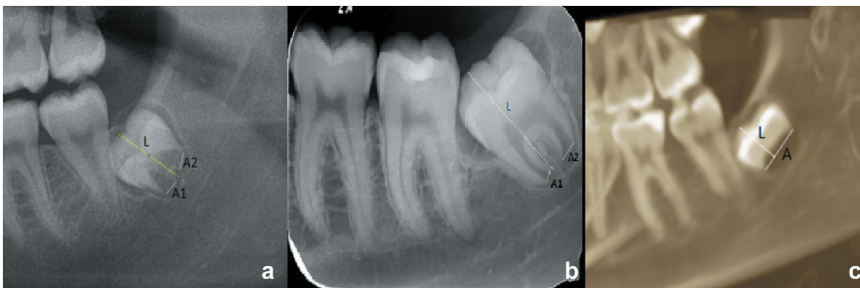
Example of measurement of A_8 and L_8 in the third molar on (a) Panoramic radiograph, (b) Periapical radiograph, (c) CBCT 3D MIP image.
